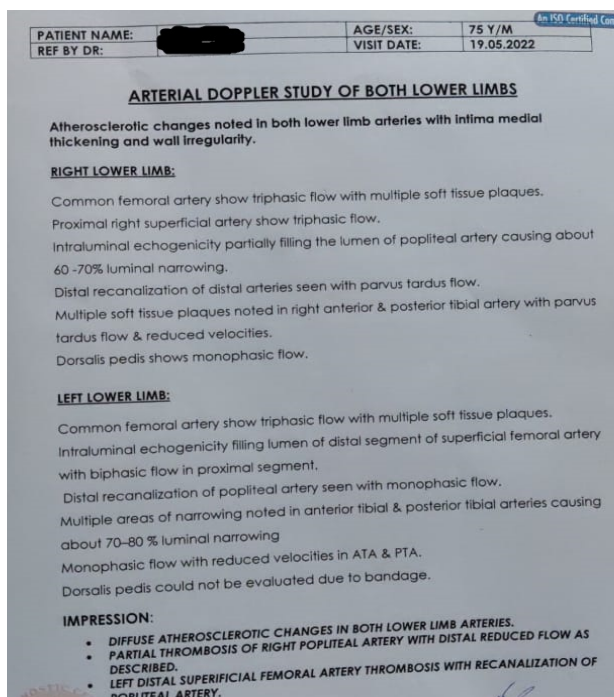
Arterial Doppler study after treatment
